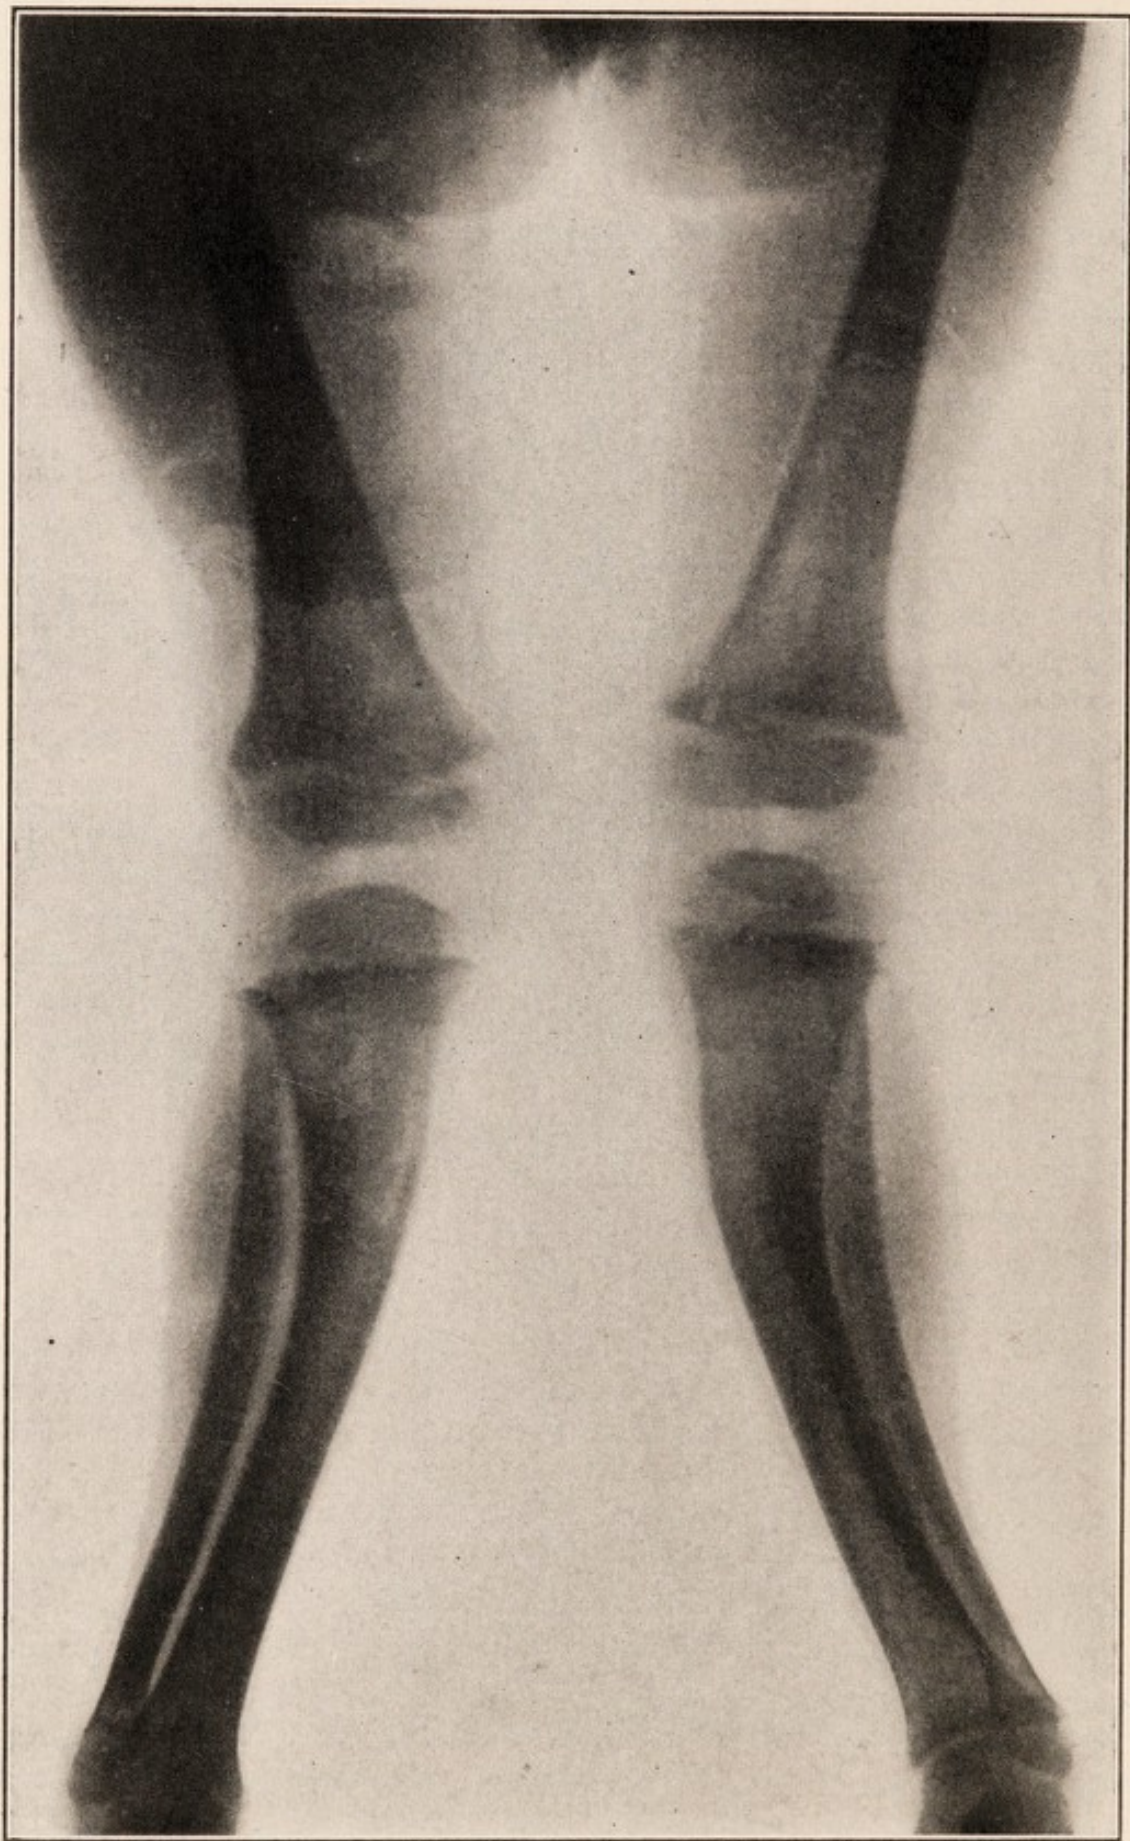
X-ray of knock-knee. Attention is called to the thickened cortex on the concave side of bones.
